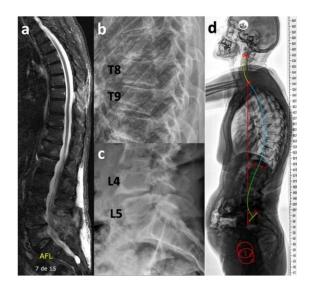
A) MRI sagittal section in STIR sequence of the spine at one month postop, showing the absence of collection in the epidural space. B and C) Localized one-year postop X-ray of the operated segments where there is no evidence of instability. D) Lateral total spine X-ray one-year postop showing preservation of the patient's sagittal profile without deformity.
